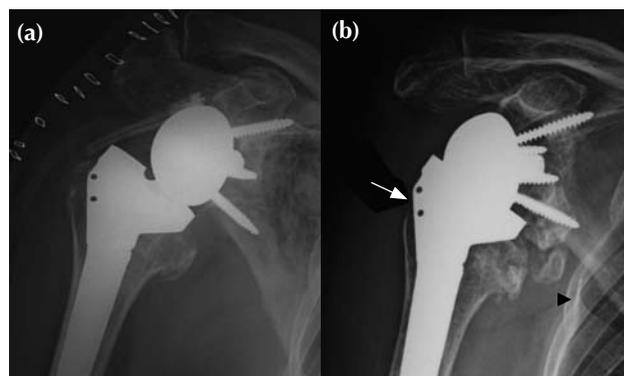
Radiographs showing (a) a Delta III prosthesis for an irreparable rotator cuff tear associated with glenohumeral osteoarthritis, and (b) scapular notching (Nerot grade 3), bone resorption in the proximal humerus (arrow), and heterotopic ossifications (arrowhead) at the 6-year follow-up.
